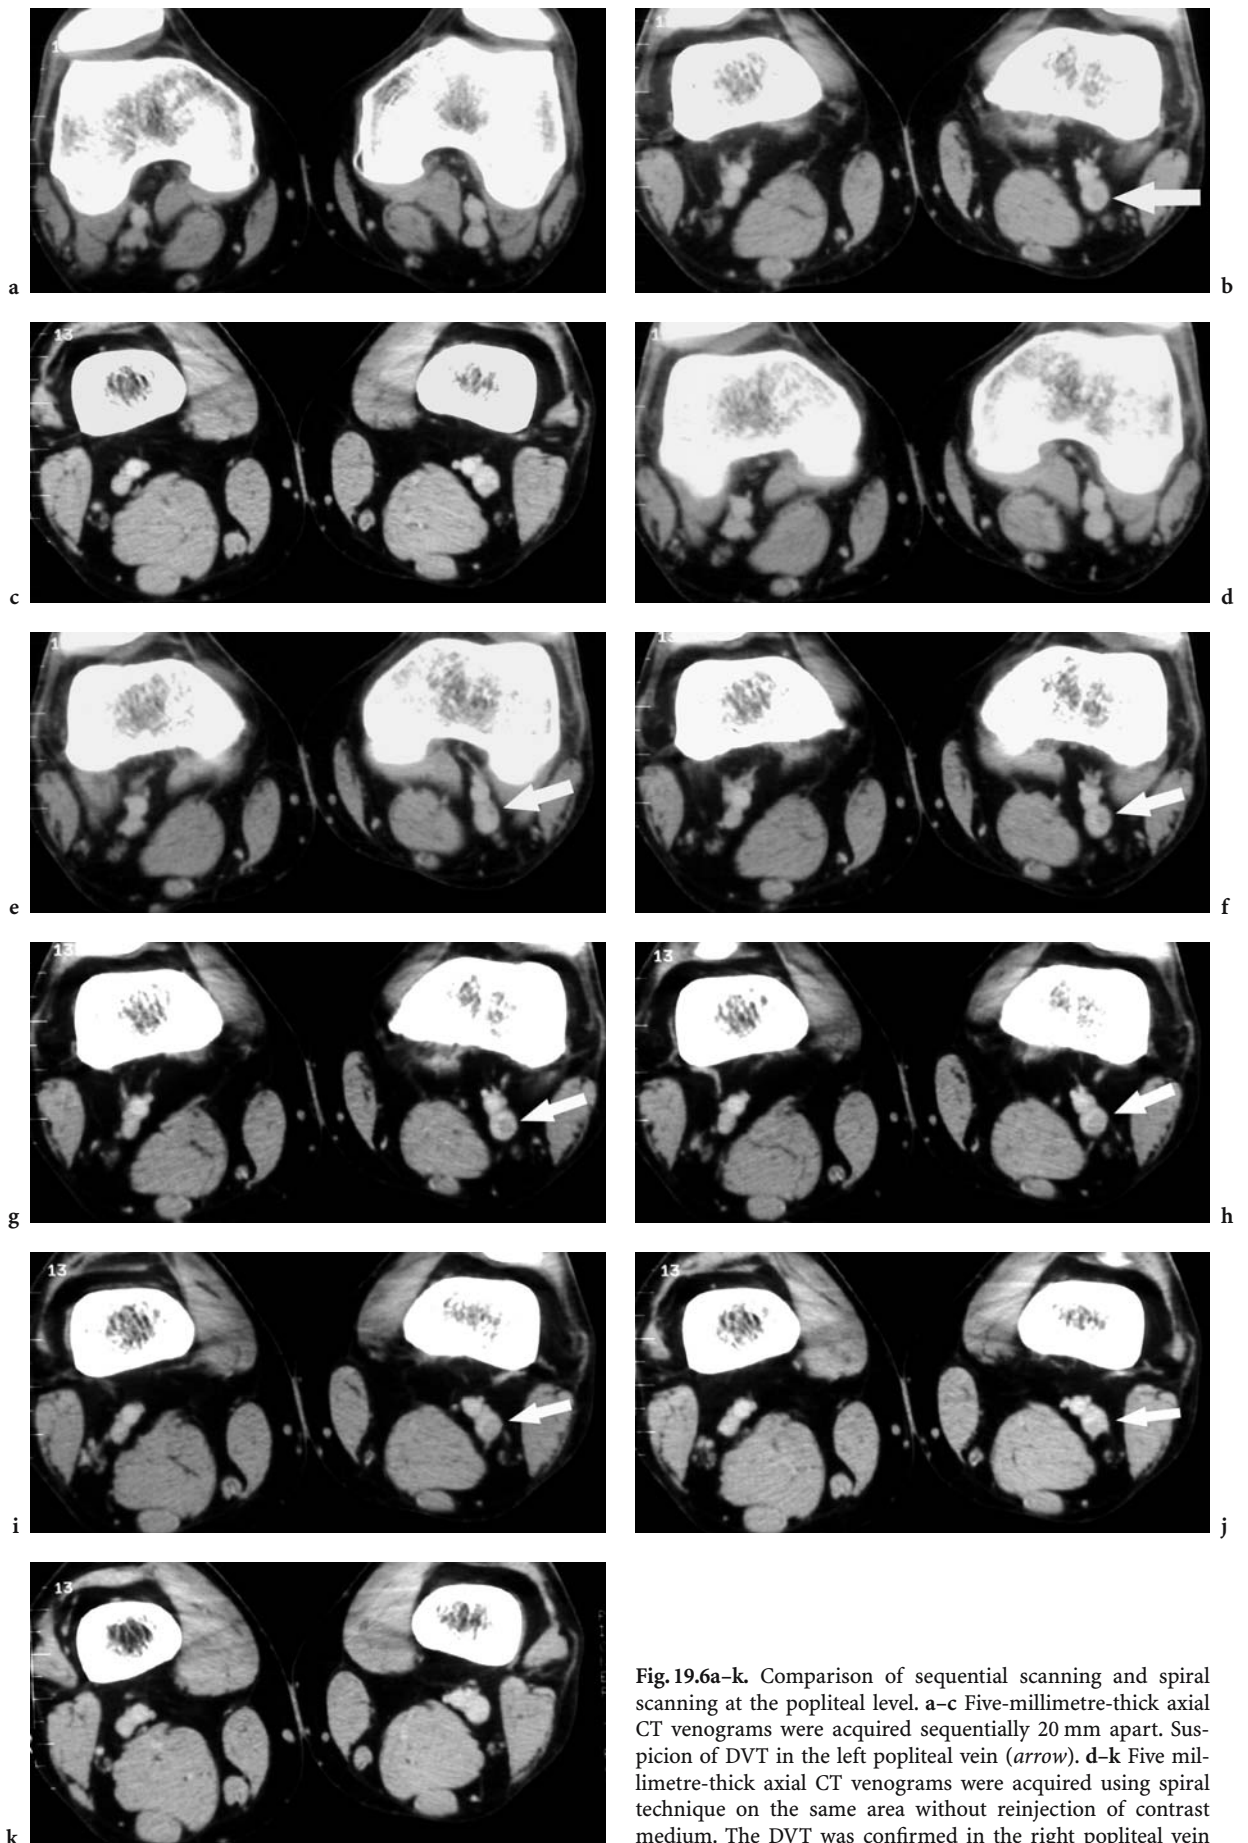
Comparison of sequential scanning and spiral scanning at the popliteal level. a-c Five-millimetre-thick axial CT venograms were acquired sequentially 20 mm apart. Suspicion of DVT in the left popliteal vein (arrow). d-k Five millimetre-thick axial CT venograms were acquired using spiral technique on the same area without reinjection of contrast medium. The DVT was confirmed in the right popliteal vein
